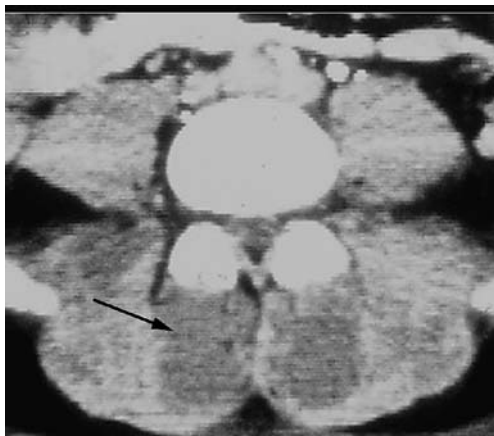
Lumbar compartmental syndrome. Diffuse edema and myonecrosis of the paravertebral lumbar muscles appearing as low-density areas on axial CT scan (*arrow*) in a 55-year-old patient who had undergone prolonged retroperitoneal surgery
